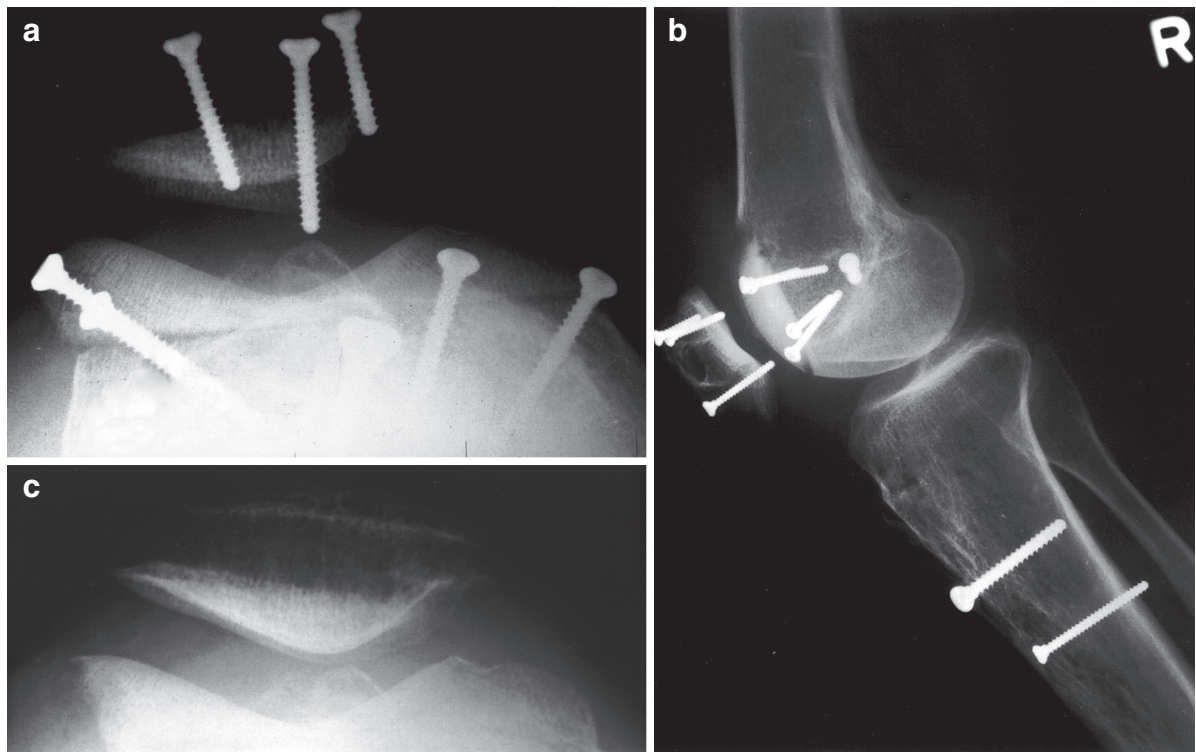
(a) Axial x-ray 2 weeks post PF fresh allograft. (b) Lateral x-ray 2 weeks post PF fresh allograft. (c) Axial x-ray 10 months post PF fresh allograft. (d) Lateral x-ray 10 months
